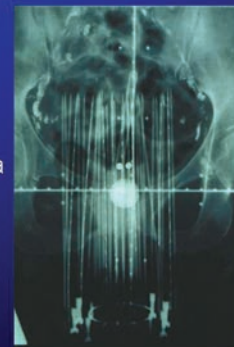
Indications for interstitial implantation and associated AP radiograph of the implanted needles.
